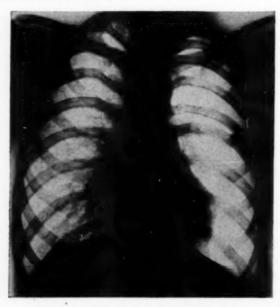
Conventional posteroanterior roentgenogram showing absence of the left hilar shadow with diminished vascular markings and narrowing of interspaces over the left hemithorax.
